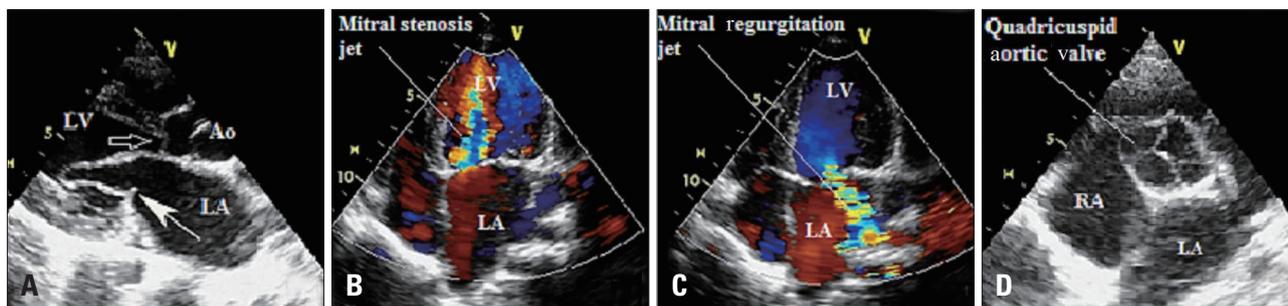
Two dimensional echocardiography with color Doppler. Parasternal long axis view (A) showing the sub aortic membrane (open arrow), partial supra mitral ring attached near the posterior mitral annulus (white solid arrow) and abnormal anterior and posterior mitral leaflets. Diastolic frame in apical four chamber view showing severe degree of mitral stenosis with color flow turbulence starting at the supra mitral ring level (B). Systolic frame in apical four chamber view showing severe eccentric mitral regurgitation (C). The basal short axis view showing the quadricuspid nature of the aortic valve (D). Ao: aorta, LA: left atria, LV: left ventricle, RV: right ventricle.
